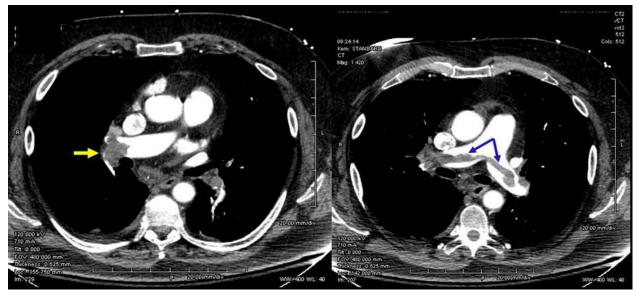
These two axial CT images show profound pulmonary emboli. On the left the embolus almost completely blocks the right pulmonary artery (yellow arrow). Right image show an extensive saddle embolus forming in both pulmonary arteries and becoming extensive. Both of these types of pulmonary emboli are life threatening and require immediate medical attention.
